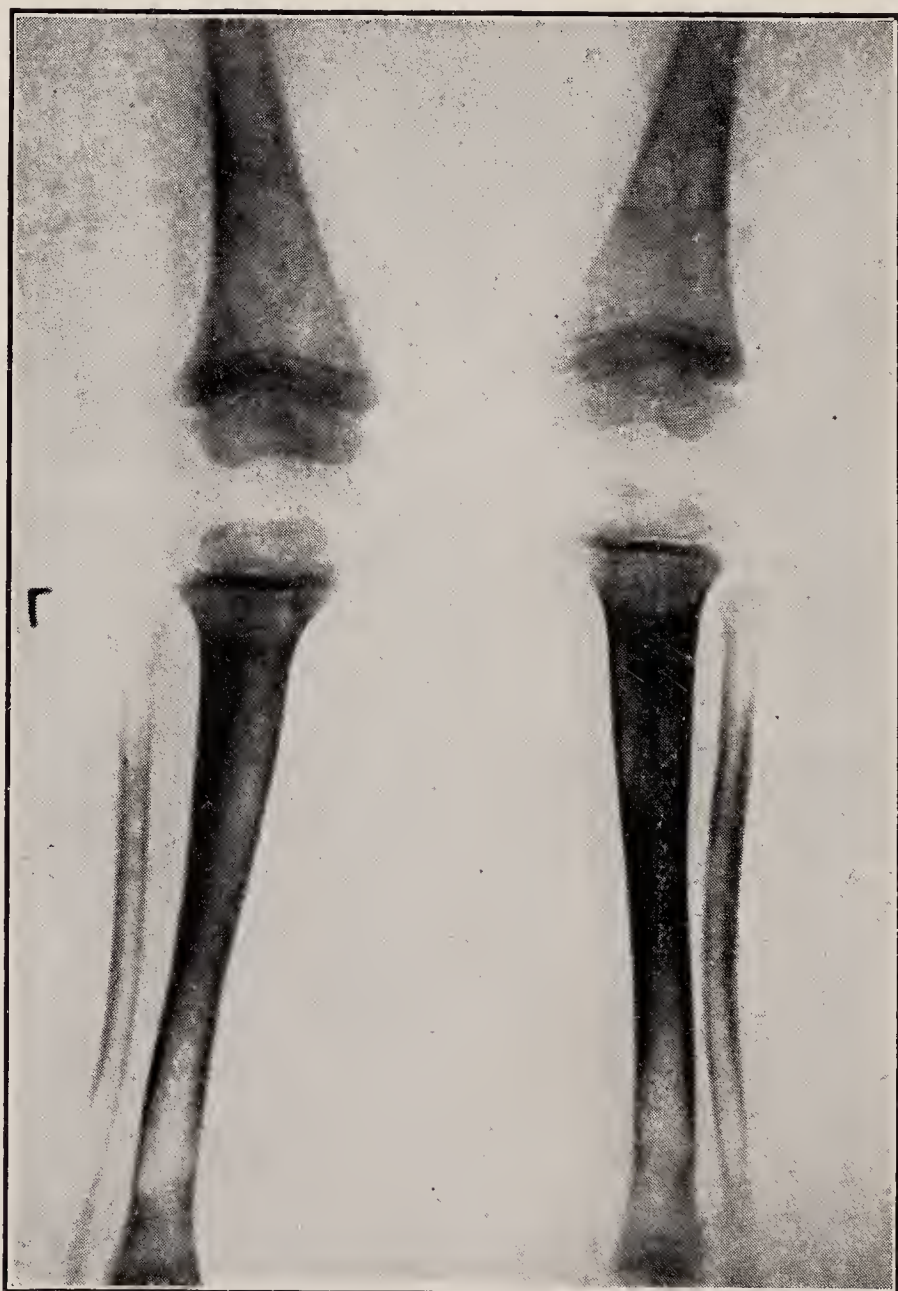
X-ray cretinism—the characteristic appearance is the dense band above the epiphyses.
